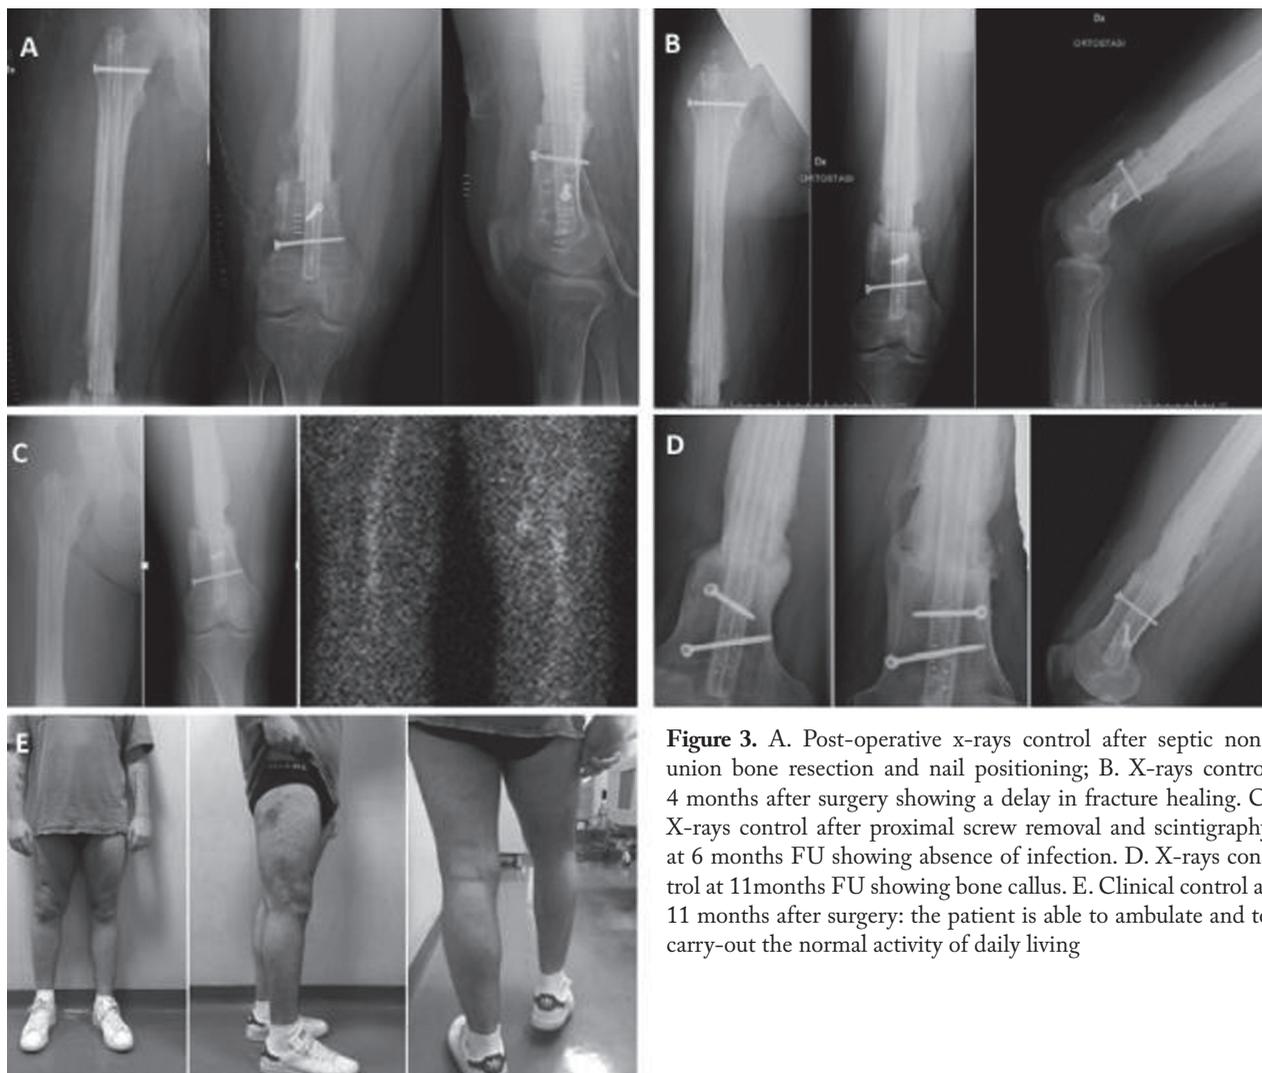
A. Post-operative x-rays control after septic non-union bone resection and nail positioning; B. X-rays control 4 months after surgery showing a delay in fracture healing. C. X-rays control after proximal screw removal and scintigraphy at 6 months FU showing absence of infection. D. X-rays control at 11 months FU showing bone callus. E. Clinical control at 11 months after surgery: the patient is able to ambulate and to carry-out the normal activity of daily living
